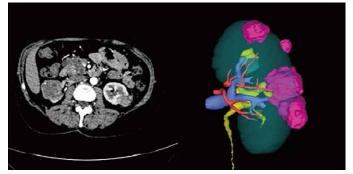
Preoperative CT scan and 3D model of FR-BOD-P* -2956 patient
